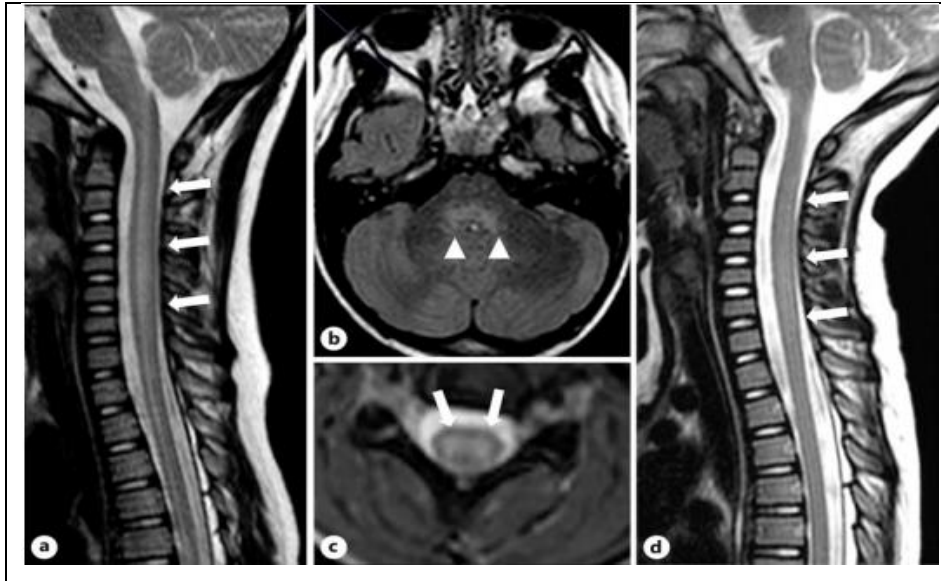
Admission (a–c) and follow-up (d) MRI results. a) Sagittal T2-weighted scan reveals widespread elevated signal intensity and significant edema of the cervical spinal cord (arrows). b) An axial T2 FLAIR-weighted picture reveals increased signal strength in the dorsal pons (arrows). c) The axial gradient-recalled echo (GRE) T2-weighted picture at the C4 level shows increased signal intensity in the core gray matter, but not in the peripheral white matter (arrows). d) MRI of the spinal cord after 4 days of therapy indicates a nearly full reduction of signal abnormalities (arrows).
